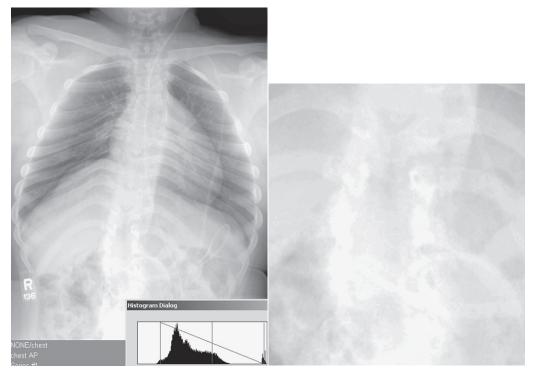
Underexposure in digital radiography causes loss of contrast in dense anatomy because of increased noise. (Courtesy Charles Willis, M.D. Anderson Cancer Center.)
